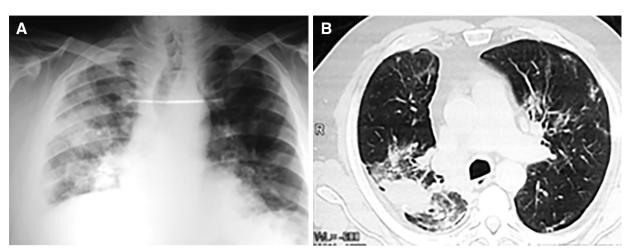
A. Chest X-ray on admission. B. Chest tomography on admission.
